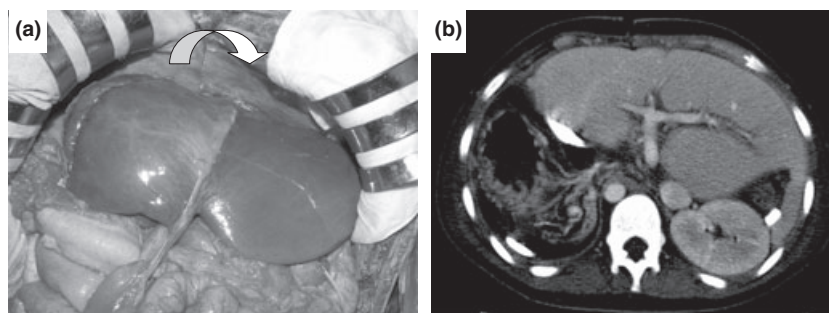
Intra- and postoperative views of the graft. (a) Intra-operative appearance of the graft positioning demonstrating slightly left-sided and clockwise rotation of the graft. (b) An abdominal CT scan at postoperative day 28 reveals a well-accommodated and regenerated graft without any torsion of the anastomosis.
